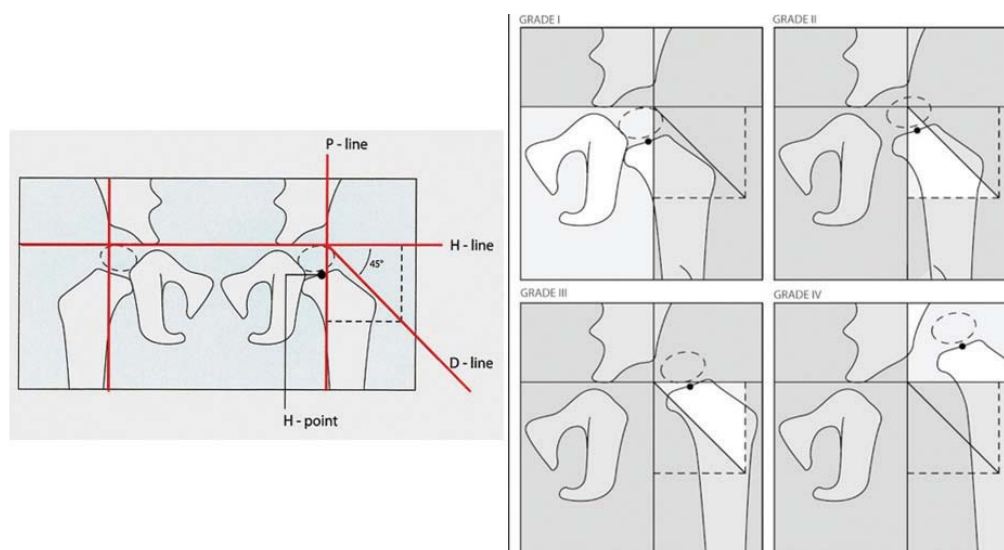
Modified Tönnis scheme. Determination of the radiographic type of the hip joint, depending on the location of the point of the femoral head center (H-point)
